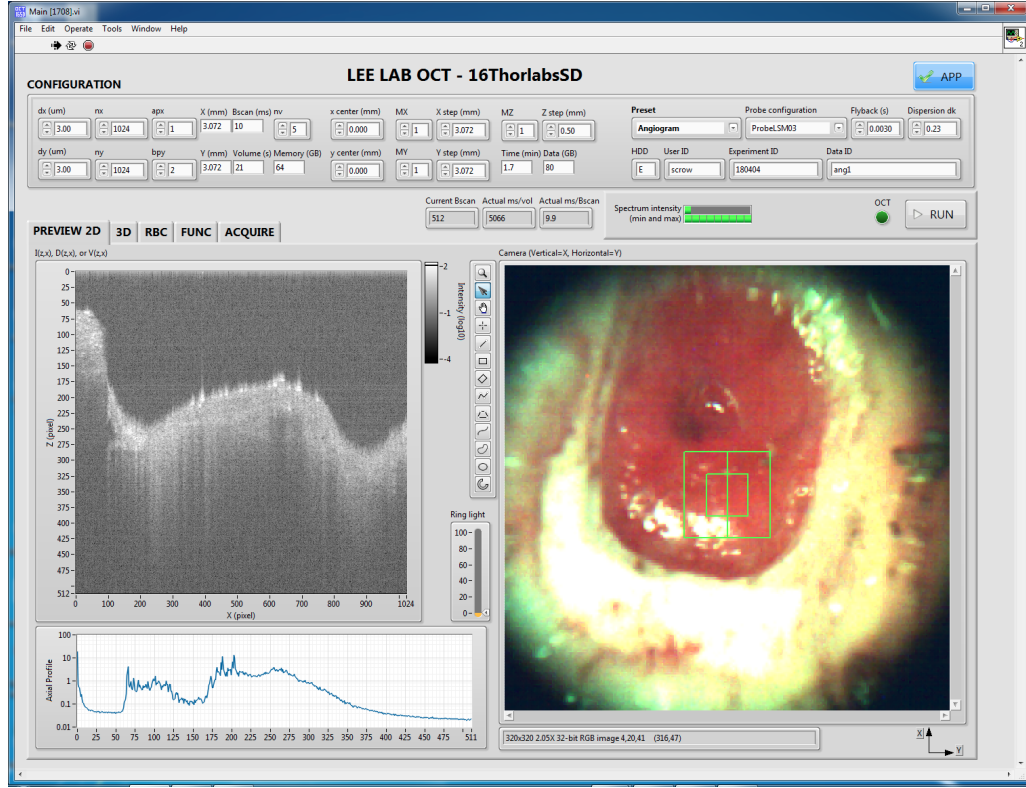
Screenshot of custom Lee Lab software for angiogram OCT (screenshots of other image acquisition settings are shown in Appendix B) dx and dy are the size of the spatial sampling steps in the x and y axis, respectively, in μm . nx and ny are the number of sampling points, again in the x and y directions respectively. apx is the number of repeating A-scans per each x point. For angiogram (ANG) and scattering coefficient (SC) images, $apx = 1$, but for doppler (DOP), $apx = 8$. bpy is the number of repeating B-scans per y point, set to 2 for ANG. For DOP and SC, $bpy=1$. nv is the number of repeating volume scans. For ANG $nv = 5$, DOP $nv = 2$, SC $nv = 2$. X and Y are the total distance that the scan cover in the x or y axis direction (a.k.a., field of view; FOV). For ANG and SC images, $X = Y = 3.072$ mm. For DOP images, the FOV is $X = Y = 1.536$ mm. MX , MY , and MZ are the numbers of volume scans in X , Y , and Z , respectively. $MX = MY = MZ = 1$ for ANG, SC and DOP. The order of volume acquisition is $nv > MX > MY > MZ$.
